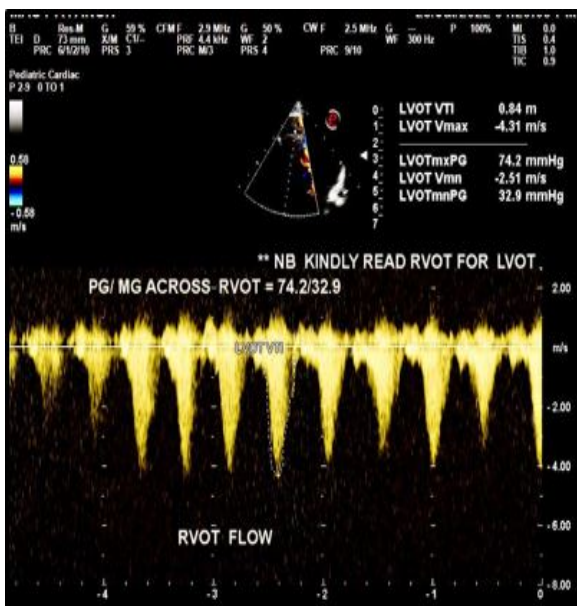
CE Doppler flow velocity across AMB (from RV apex to RV cavity).
